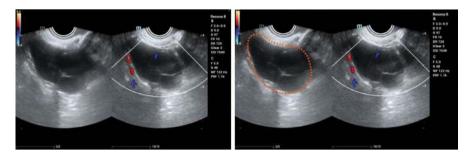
Left: A gray-scale ultrasound image of a multicystic chocolate cyst; Right: A color Doppler ultrasound image showing blood flow signals in the cyst wall and its septa. The cyst is circled in orange
